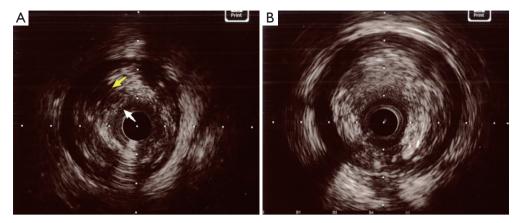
An example of IVUS imaging showing PR and non-PR. (A) IVUS of PR showing the presence of plaque with fibrous-cap disruption (white arrow) and cavity (yellow arrow). (B) The IVUS of non-PR showing the presence of plaque without fibrous-cap disruption and cavity. IVUS, intravascular ultrasound; PR, plaque rupture.
